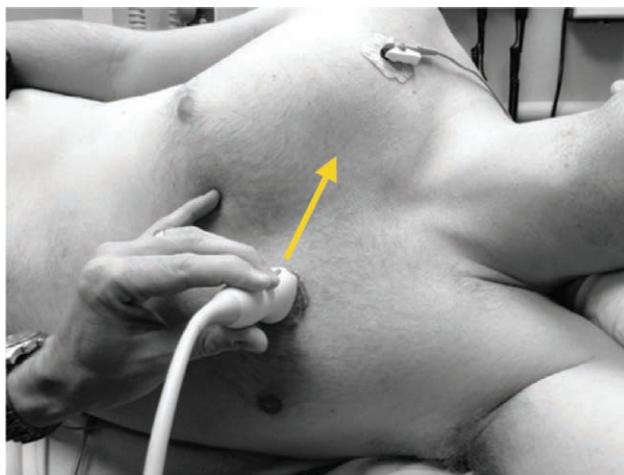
Probe position for the parasternal long axis (PLAX.) The probe is just to the left of the sternum, in the fourth intercostal space (though this location will vary), with the indicator pointing toward the patient’s right shoulder. The indicator location and direction is shown by the yellow arrow.
